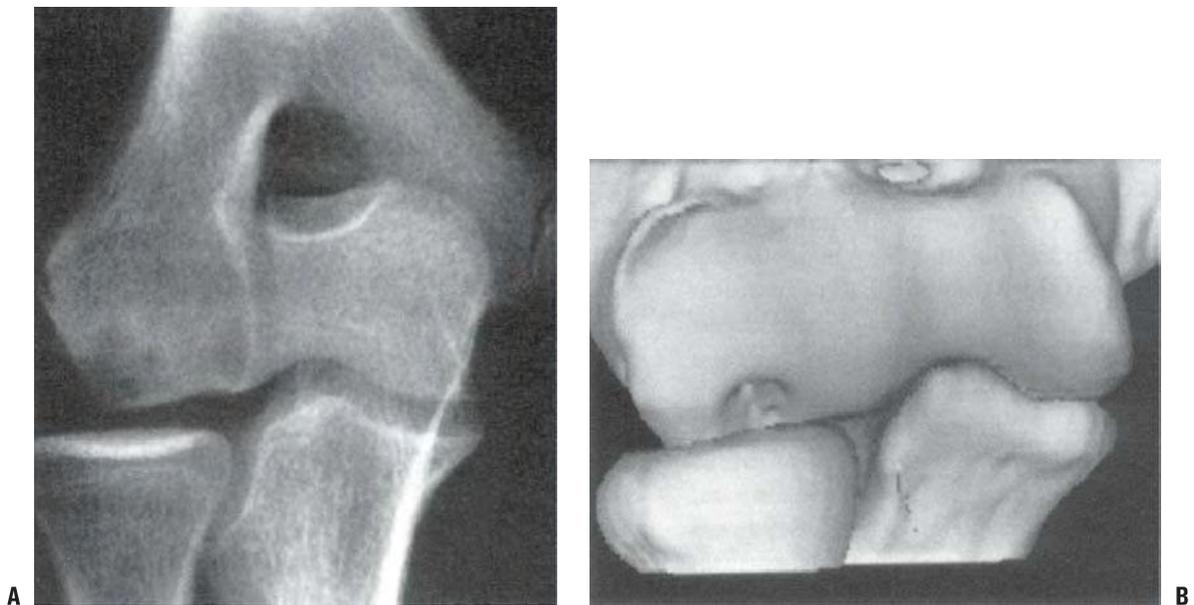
Osteochondral lesion of the capitellum in a 15-year-old baseball player with a painful elbow. A: The subchondral plate of the capitellum appears intact. Subchondral cysts are present. B: The CT scan with three-dimensional reconstruction demonstrates the bony defect of the capitellum, including loss of the subchondral plate in that area.
